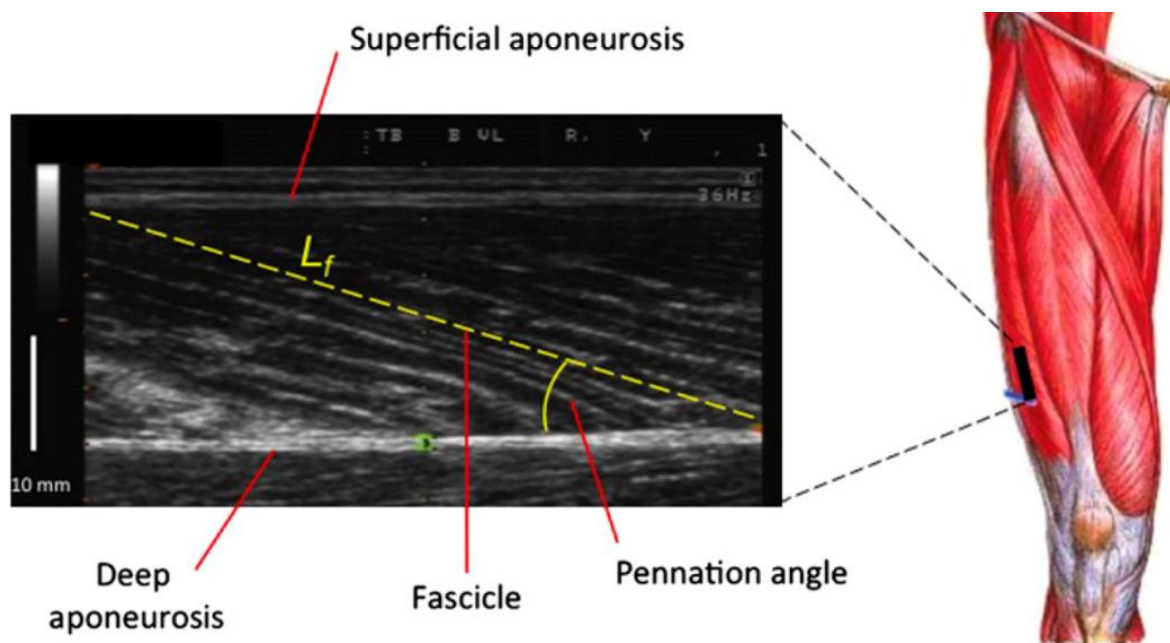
Representative longitudinal B-mode Ultrasound image of Vastus lateralis (VL) muscle architecture. Yellow dotted line denotes the length of a muscle fascicle (L_f). (Adapted from Franchi et al, 2014).
